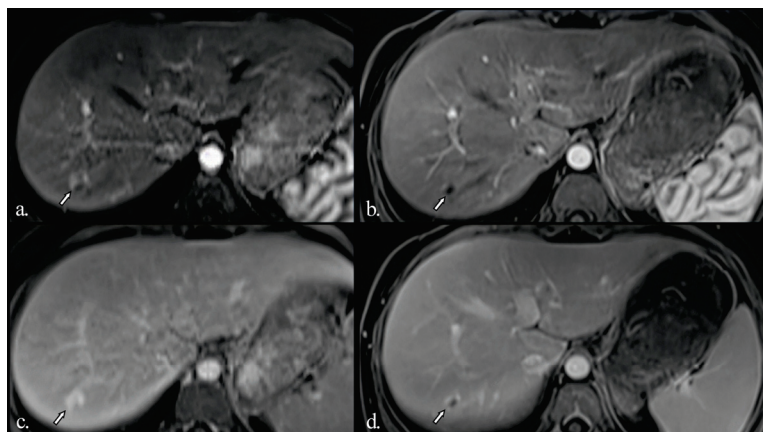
Subsequent MRI examinations after 5 years (a,c) and 9 years (b,d) of Etanercept treatment since the initial assessment. Gd-enhanced fat-saturated T1-weighted images in the arterial (a,b) and late (c,d) phases. Only one lesion (arrow) remains visible, showing hyperenhancement in the periphery and a central scar with progressive, incomplete filling in the late phases. The lesion has shrunk in the last examination.
